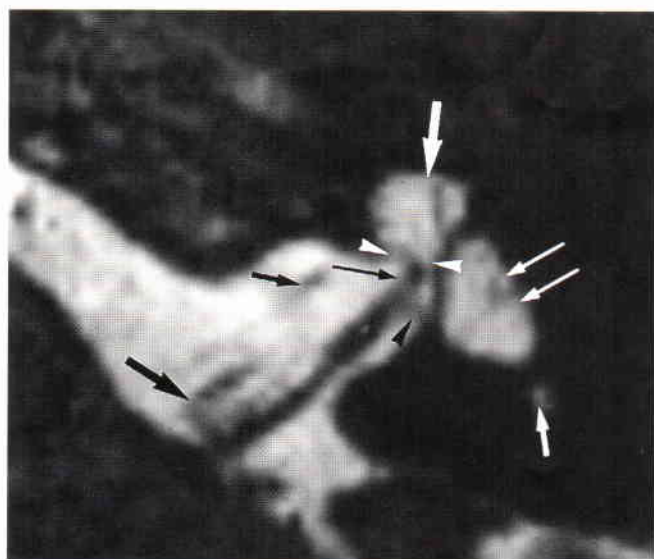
Axial 0.7-mm-thick 3DFT-CISS MR images made at the level of the inferior part of the internal auditory canal. The cochlea has no second or apical turns and the modiolus is absent, making the cochlea appear as a cystic fluid-filled structure (*large white arrow*). The enlarged vestibule is again seen (*long white arrows*) and a broad connection between the abnormal cochlea and the broad fundus of the internal auditory canal is visible (*white arrowheads*). These findings indicate a potential “gusher ear.” The cochlear branch (*long black arrow*) and inferior vestibular branch of the vestibulocochlear nerve (*black arrowhead*) are visible on this image. Also seen are the facial nerve (*large black arrow*), vascular loop in the internal auditory canal (*small black arrow*) and posterior semicircular canal (*small white arrow*)
